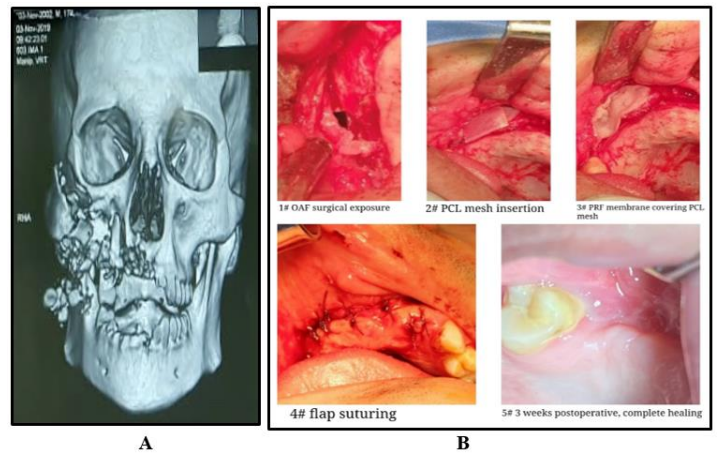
A. 3D CT scan B. Pictures show step-by-step procedure of case No. 3.
